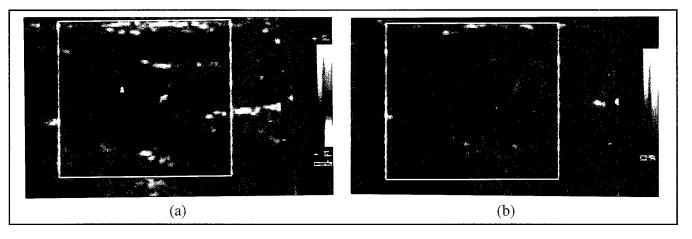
Doppler images of a patient with infiltrating carcinoma: (a) color Doppler image, (b) power Doppler image.
